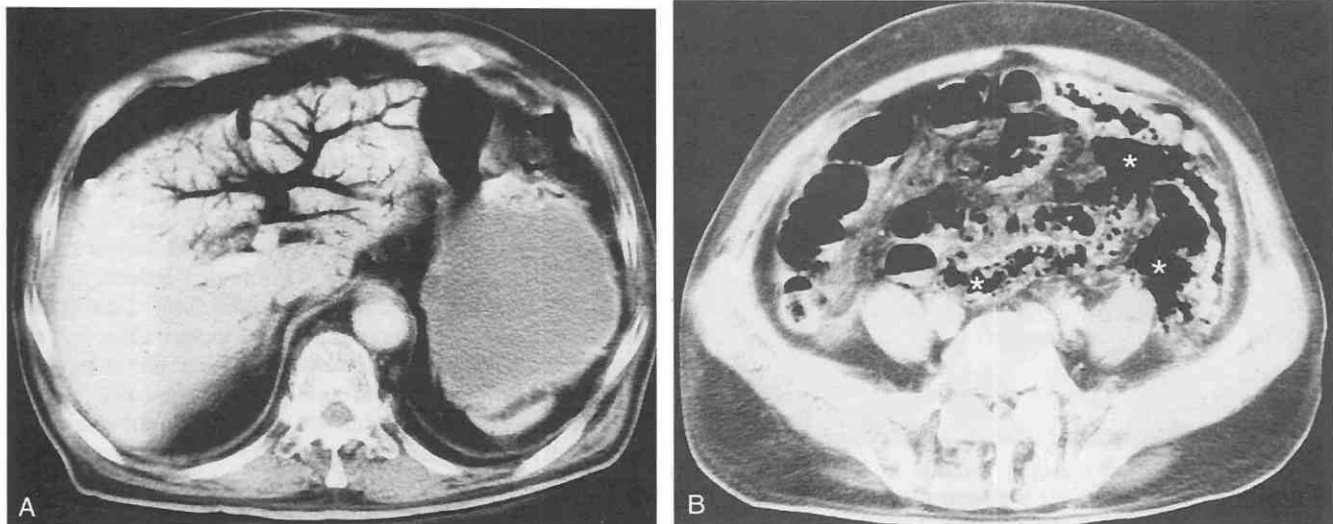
Chemotherapy-induced enteropathy with diffuse intestinal necrosis in a patient who received chemotherapy for central nervous system lymphoma. A, CT scan shows extensive intrahepatic portal venous gas. B, CT scan shows intestinal pneumatosis (asterisks) and gas in the mesenteric vascular branches. (From Rha SE, Ha HK, Lee SH, et al: CT and MR imaging findings of bowel ischemia according to the various primary causes. *Radiographics* 20:29-42, 2000.)
